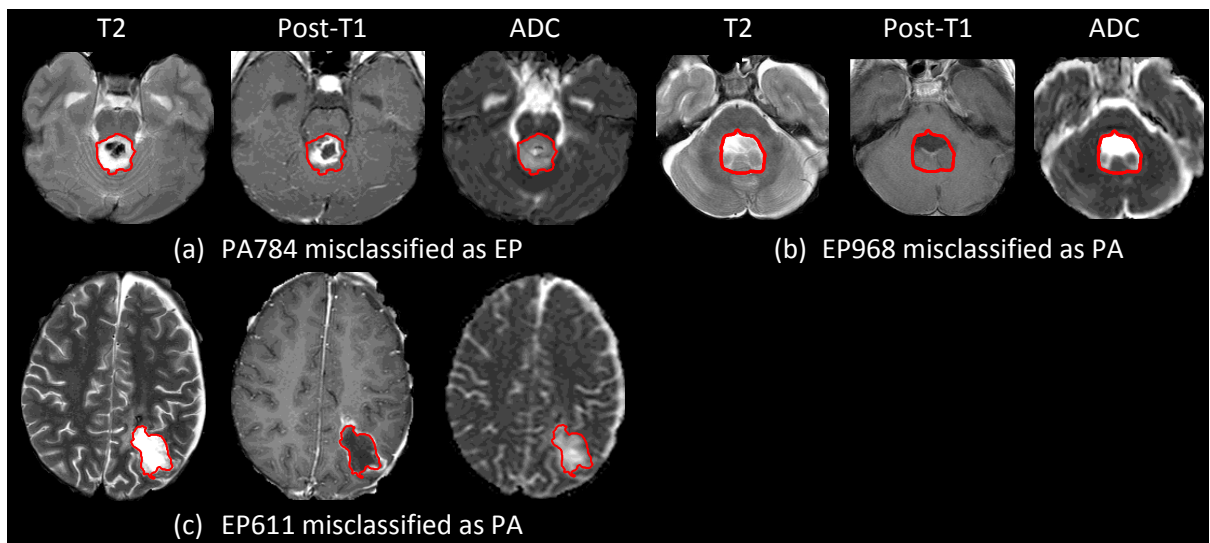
Three cases misclassified by the combined multimodal MRI based TA approach.
